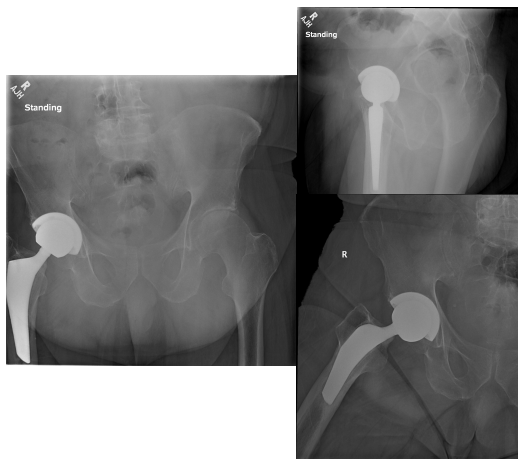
Anteroposterior and lateral standing radiographs of the pelvis and right hip demonstrating well aligned and intact total hip arthroplasty components without evidence of fracture, migration, or radiolucency.
